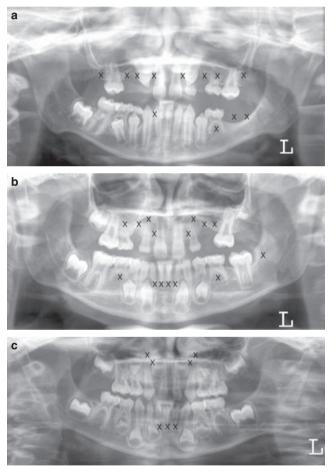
Panorex radiographs. Each missing permanent tooth is indicated with x. Missing deciduous teeth are not indicated. (a) V.H.J. (b) V.H.A. (c) V.H.L.
